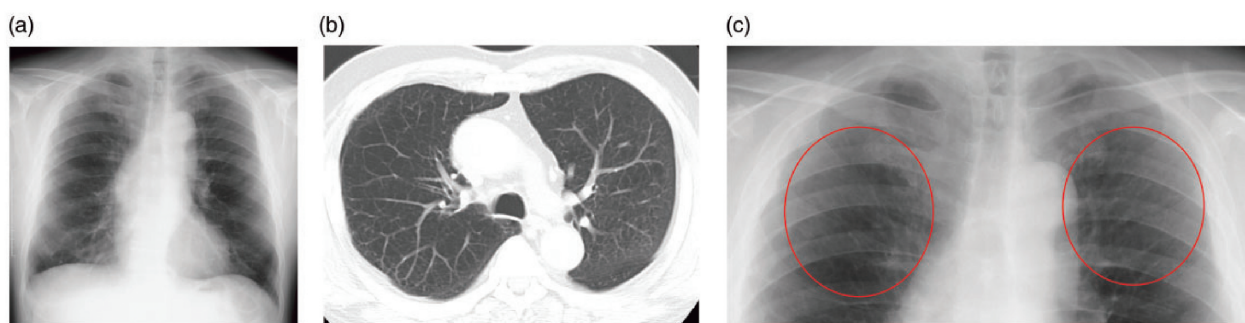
(a) An 81-year-old man with an exposure duration of 34 years. CR was judged as profusion 1/1. (b) Computed tomography images revealed pulmonary emphysema with a few small opacities in the lung parenchyma. (c) Magnified image of the upper lung fields of CR (a). There appear to be small nodules in the upper lung fields (circles). CR, chest radiography.
